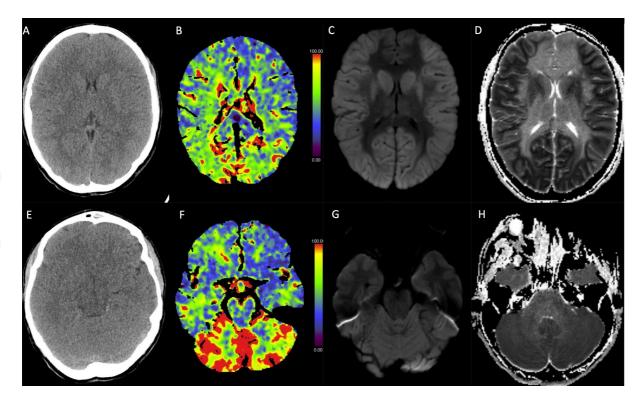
Nonenhanced computed tomography (NECT) (A and E), CBF (B and F), DWI (C and G) and ADC (D and H) at the level of the basal ganglia (upper row) and of the cerebellum (lower row). NECT, obtained directly after resuscitation, shows diffuse effacement of the sulci, but the gray-white matter differentiation, as well as the differentiation of the basal ganglia, can still be seen. CBF shows global perfusion reduction of the gray matter (cortex and basal ganglia), but the perfusion of the cerebellum is preserved. DWI and ADC obtained 2 days after resuscitation showing diffuse restricted diffusion in the cortex and basal ganglia.
